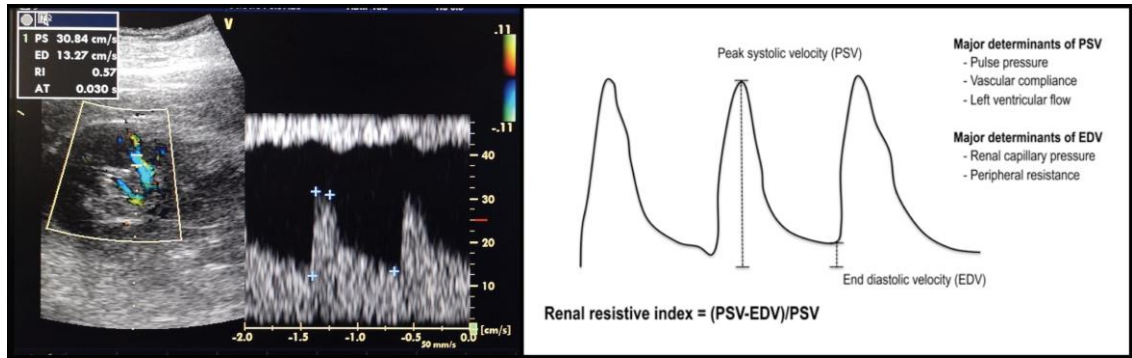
The Doppler ultrasonographic measurement of RRI and its influencing factors
